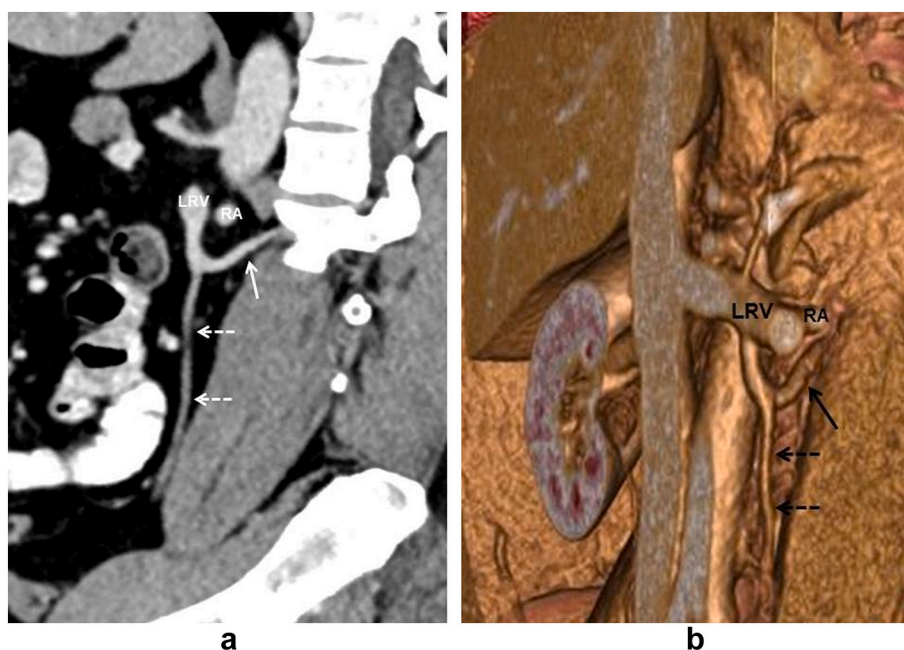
Sagittal plane contrast-enhanced curved MPR CT image (a) and coronal oblique VRT image (b) show merging of the ALCV (solid arrow) and left testicular vein (dashed arrows) in a 36-year-old male patient. LRV: Left renal vein RA: Left renal artery.
